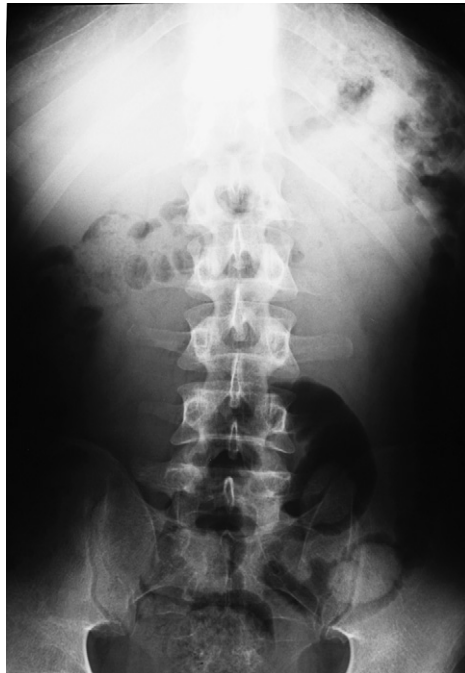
Body packing with sigmoid colon condoms seen on plain films. (Courtesy of Koenraad Morteale, MD, Boston, MA.)
